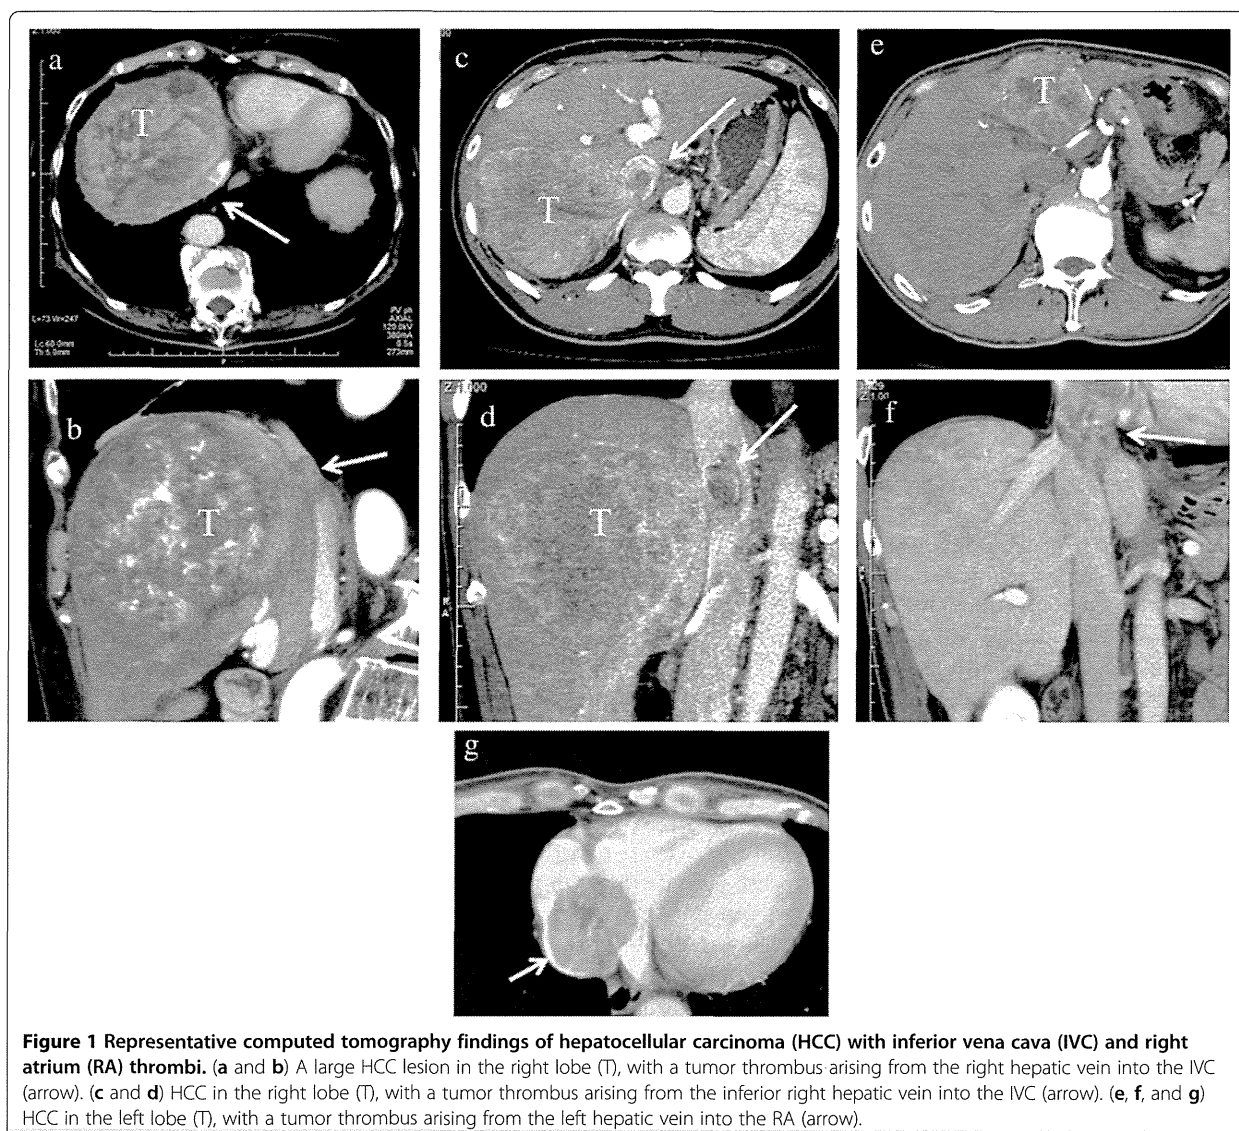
Representative computed tomography findings of hepatocellular carcinoma (HCC) with inferior vena cava (IVC) and right atrium (RA) thrombi. (a and b) A large HCC lesion in the right lobe (T), with a tumor thrombus arising from the right hepatic vein into the IVC (arrow). (c and d) HCC in the right lobe (T), with a tumor thrombus arising from the inferior right hepatic vein into the IVC (arrow). (e, f, and g) HCC in the left lobe (T), with a tumor thrombus arising from the left hepatic vein into the RA (arrow).
